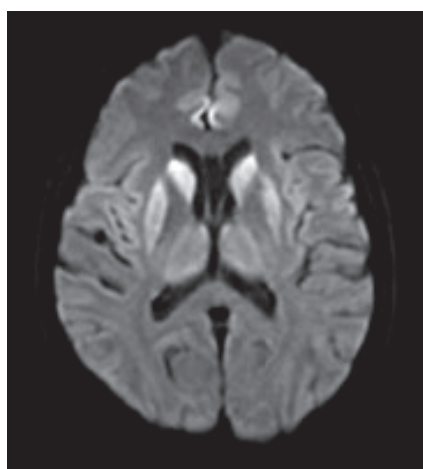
MRI imaging of patient 1 – involvement of both caudate nuclei, putamens and thalamic areas, edematous basal ganglia with symmetrical hyperintense changes
